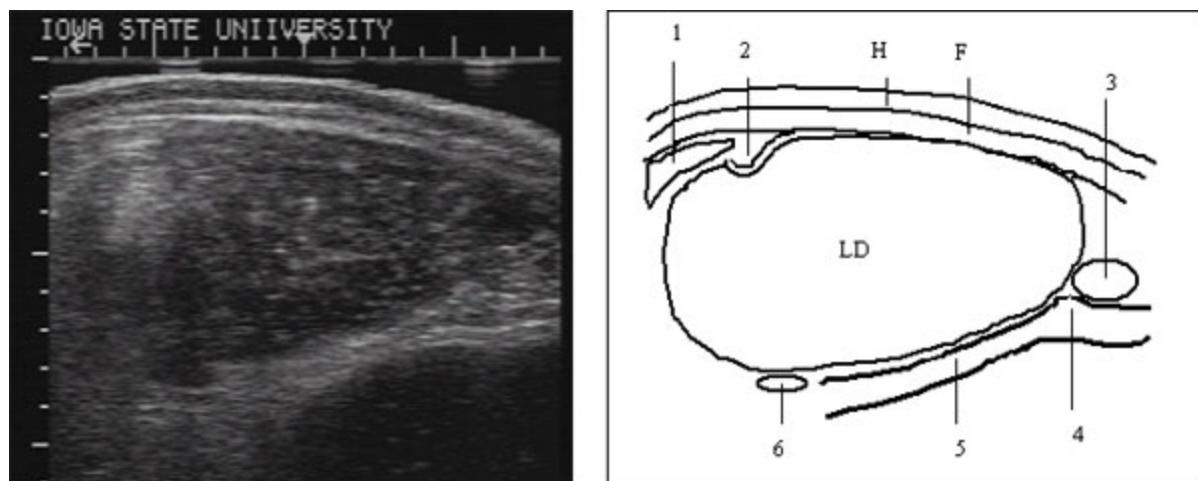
Cross-sectional ultrasound image and outline of important landmarks @ 12-13 rib, where a carcass would be broken into quarters.
